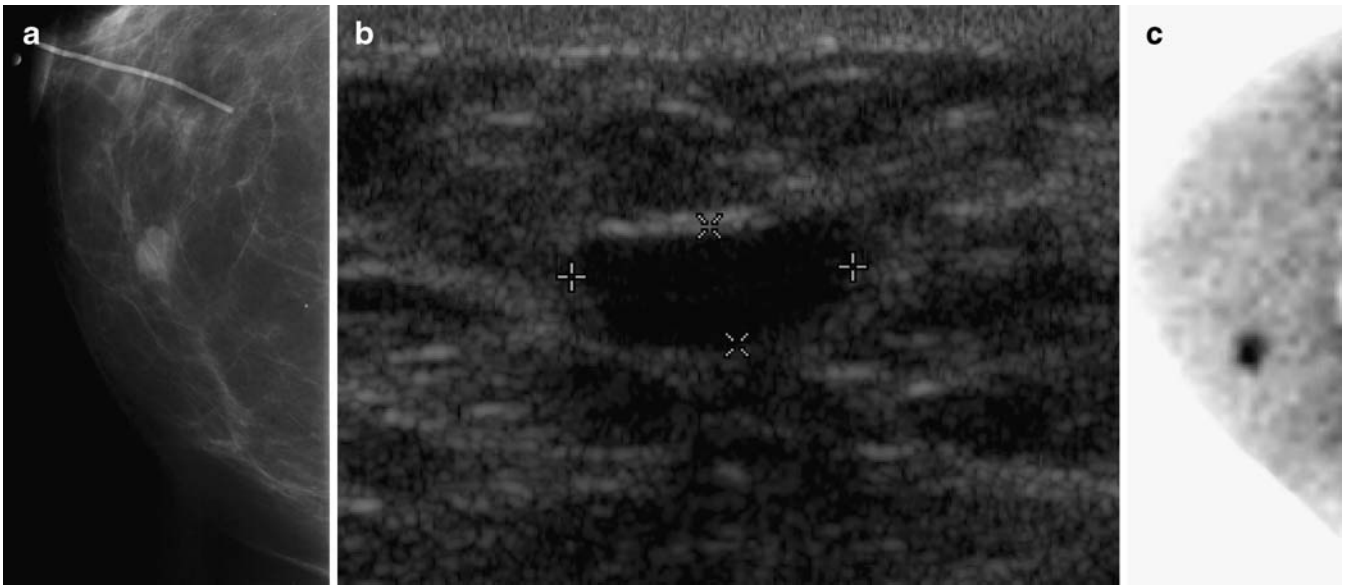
Biopsy-proven low-grade ductal carcinoma in-situ, in which sestamibi scintimammogram is more accurate than ultrasound. A. Mammogram in craniocaudal projection shows an ovoid mass in the inner aspect. B. Ultrasound shows an anechoic ovoid mass consistent with a benign cyst. C. Sestamibi scintimammogram in the craniocaudal projection shows an ovoid focus of increased uptake. (Images in figure 3 courtesy of Dillon)
